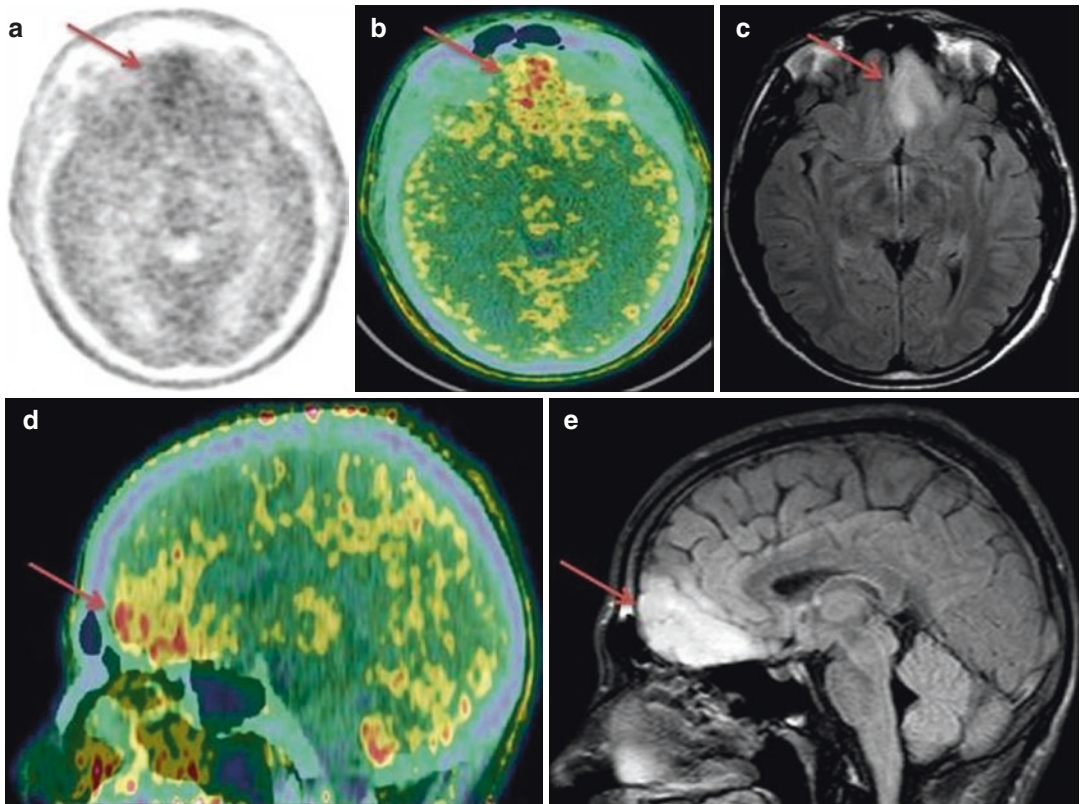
Patient with astrocytoma. Axial PET (a) and PET/CT (b) views and sagittal PET/CT views (d) show intense ^{18}F -DOPA uptake in the left frontal region, in correspondence of a hyperintense lesion on related axial (c) and sagittal (e) *Fluid Attenuated Inversion Recovery* MRI views
